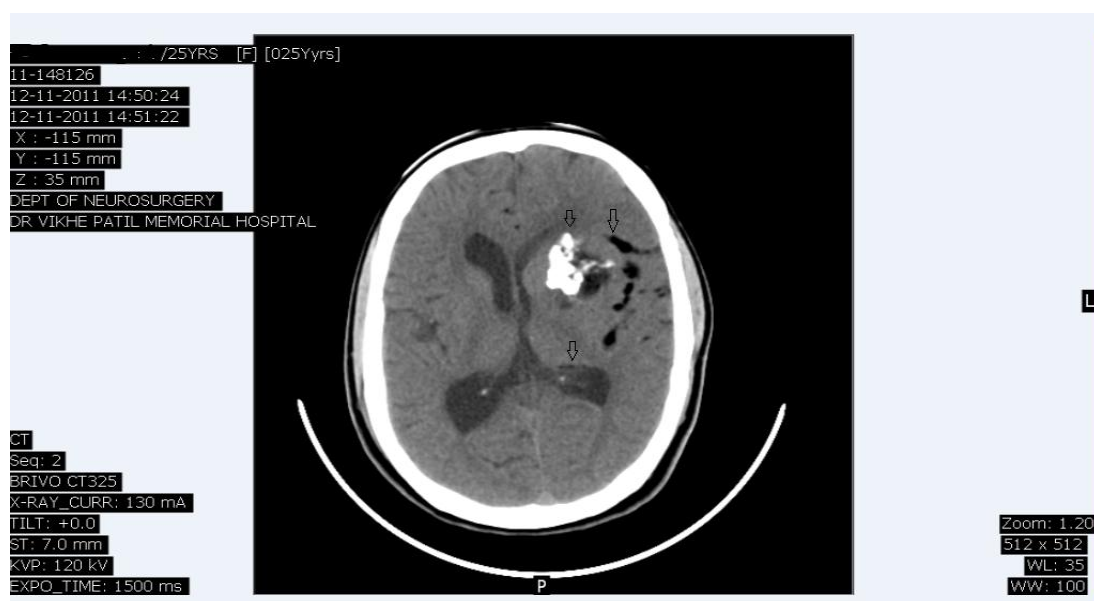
Unenhanced CT scan of brain shows fat density droplets in subarachnoid space and also within the left lateral ventricle. Lobulated fat component is noted within the lesion
